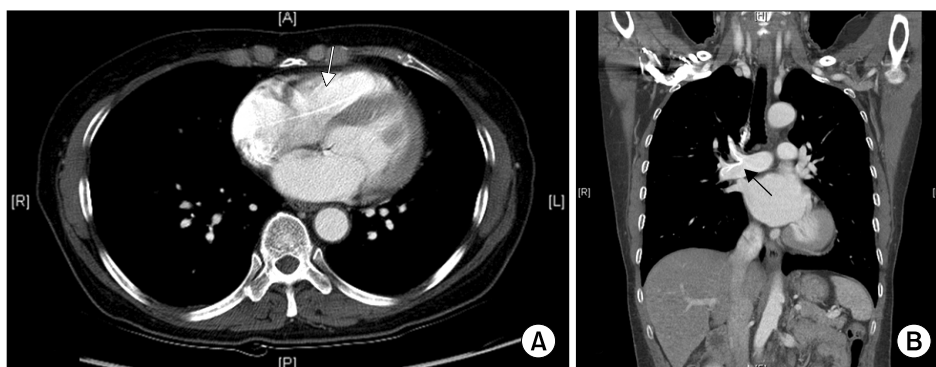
A preoperative computed tomography scan. (A) A long, linear body is in the right side of the heart (arrow). (B) Fragmented pieces are present in the right pulmonary artery (arrow).
